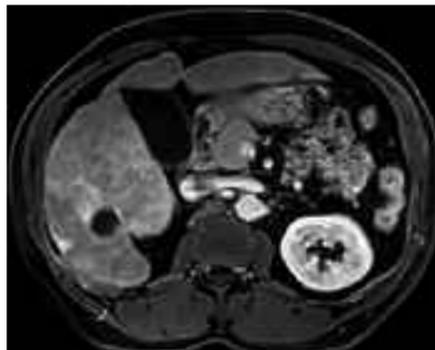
After 14 days, in the follow-up MRI, we found a complete devascularized HCC nodule in the arterial and venous phase without vital tumor using the liver-specific contrast medium Primovist (Bayer Vital, Germany).
